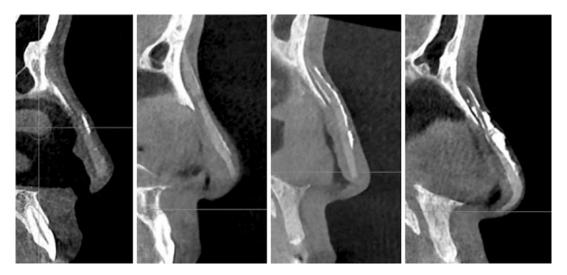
Various features of calcification on CT scan
